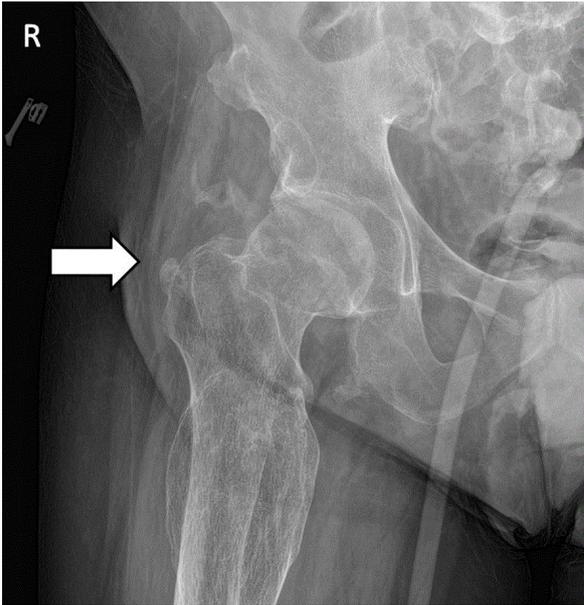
Radiograph of the hip showed neurogenic heterotopic ossification before extracorporeal shock wave therapy treatment
